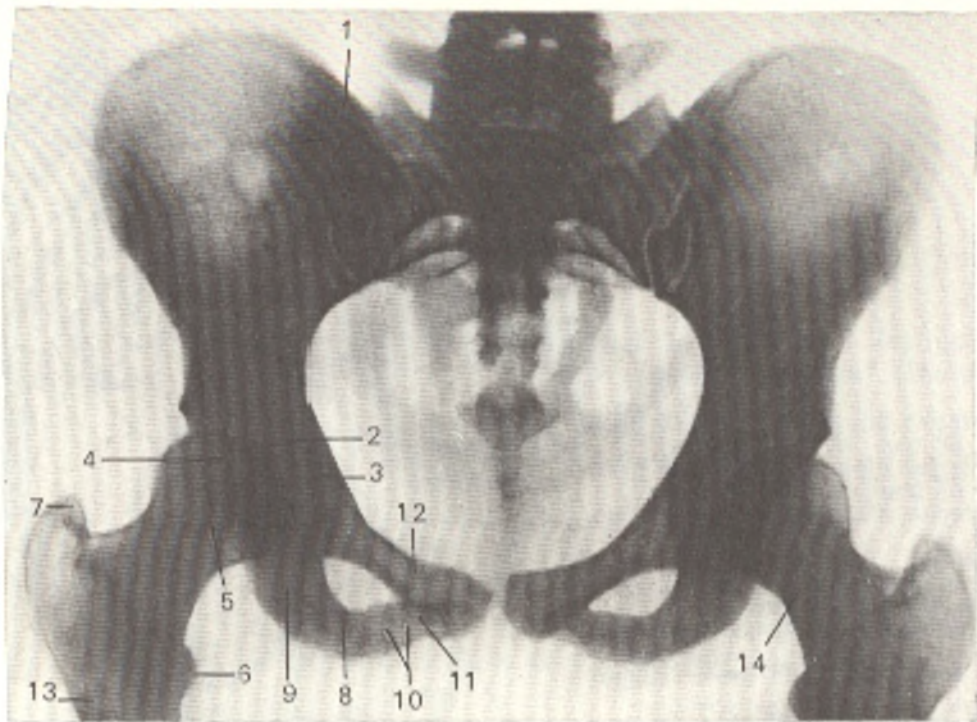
Radiograph of pelvis and hip joint of female.
